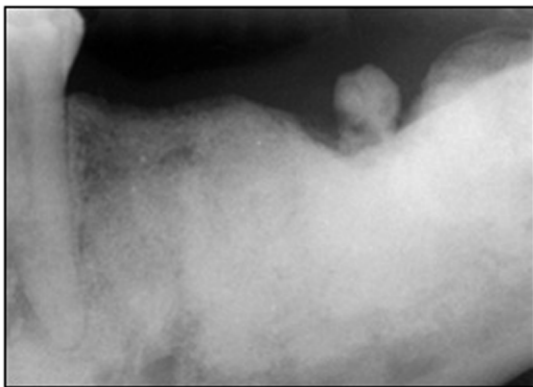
Initial periapical radiograph showing radiopaque masses.
